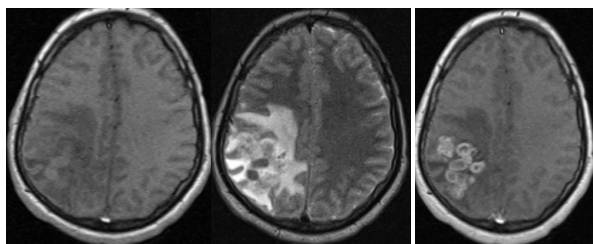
A 26 years old male presented with visual loss of seven months. MRI of the brain showed intermediate intensity on T1W (left) image, Hypo-intense on T2W image (middle image) with perilesional edema. Conglomerate ring enhancing multiple lesions (right image) with significant peri-lesional edema are noted on T1W post contrast image.
